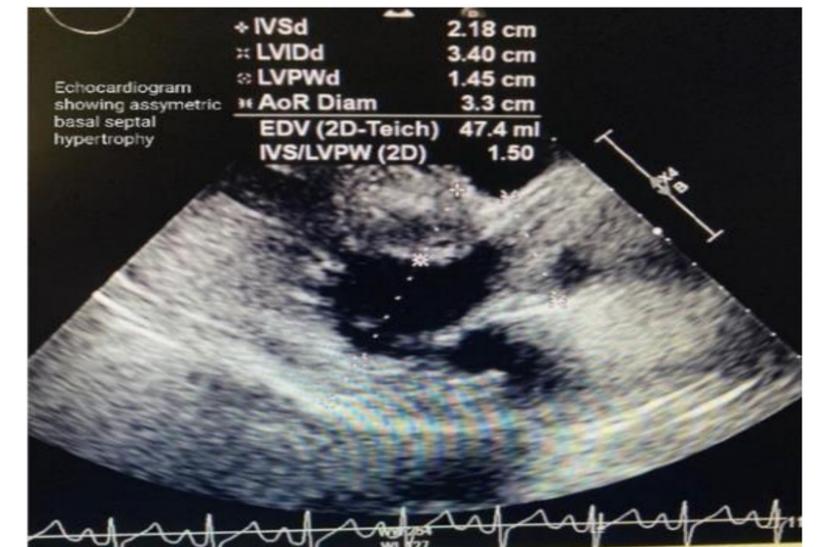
Echocardiogram showing asymmetric basal septal hypertrophy.
